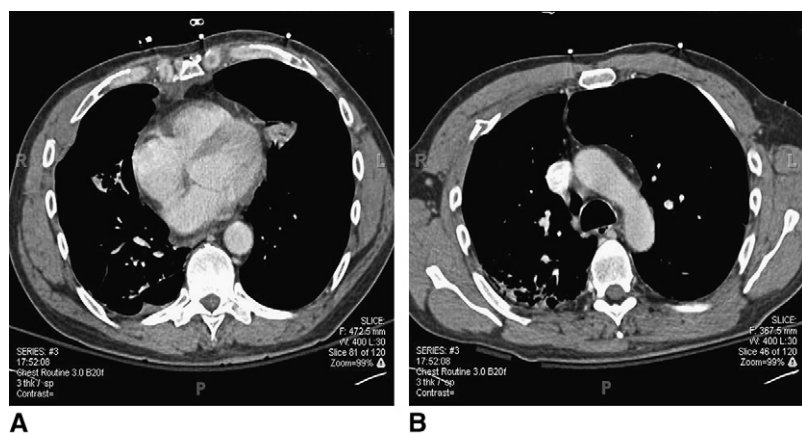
A, Regular shape of the right atrium on initial CT scan. B, Normal junction of the azygos vein to the superior vena cava at admission.
